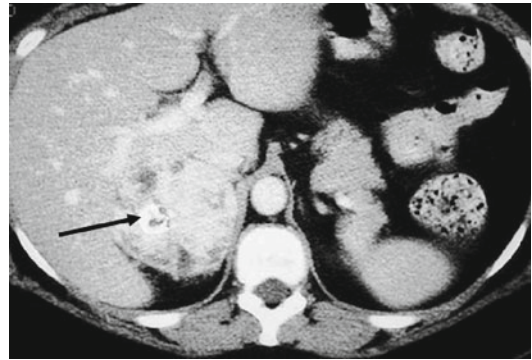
A 56-year-old female with a pheochromocytoma. Contrast-enhanced CT image demonstrates a 5-cm hypervascular mass containing calcification (*arrow*) in the right adrenal gland. Although its imaging appearance is nonspecific, the patient had a history of “panic attacks” and laboratory evidence to support the diagnosis of pheochromocytoma. At surgical pathology, a pheochromocytoma was diagnosed (Used with permission from Hindman and Israel [15])
